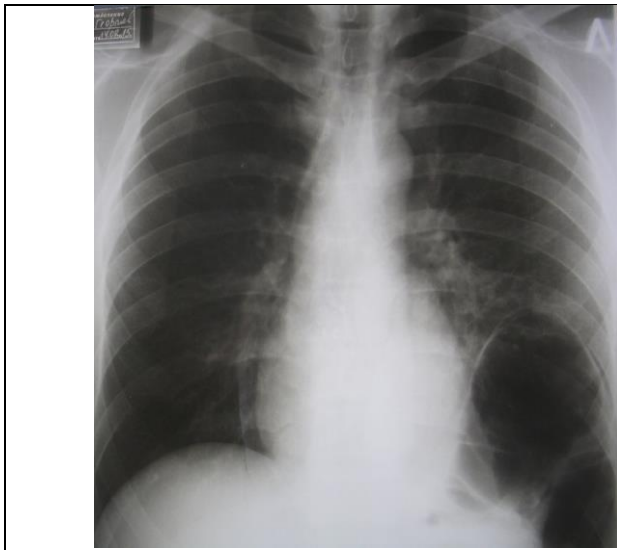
Chest X-Ray reveals colonic bubble in the left thoracic cavity / (the author's database).
